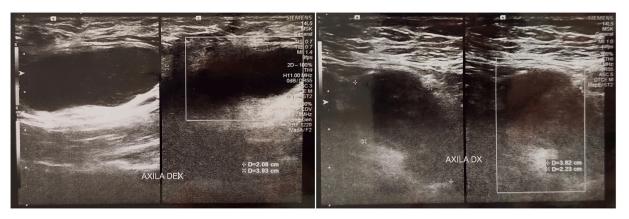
Ultrasonography examination showed multiple lymphadenopathies.
